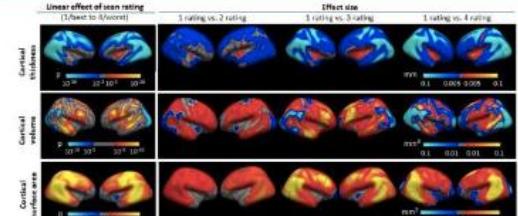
Effects of scan artifacts detected by manual review on structural MRI indices from 5,123 children ages 9-10 in the ABCD Study. Analyses were covaried by age, sex, scanner, and ICV. Of the 356 ANOVAs testing for differences in ROI by ratings, all but 41 demonstrated significant effects of QC ratings ($p<.05$, FDR), with higher ratings tending to deflate cortical thickness and to inflate volume and surface area.
